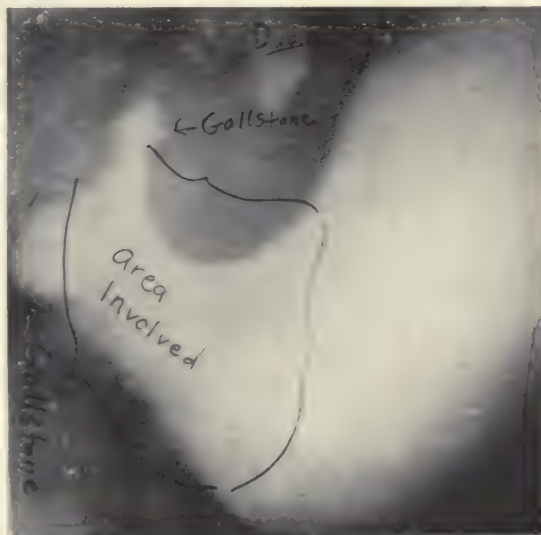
Roentgenogram of stomach showing area of involvement in linitis plastica.
